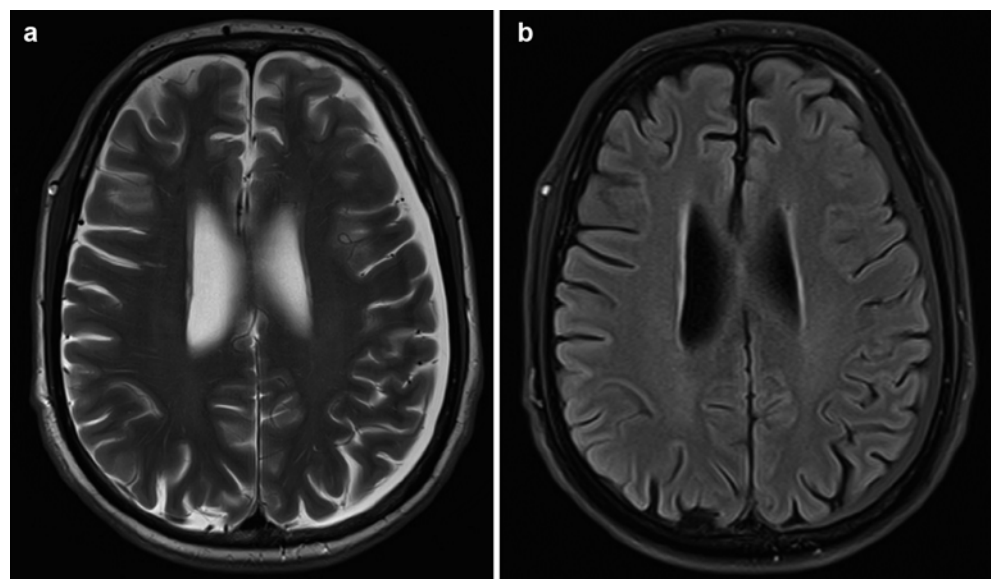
(a, b) Chronic left subdural hematoma. MRI examination, including (a) axial TSE T2-weighted image and (b) axial turbo-FLAIR image with fat saturation. On the T2-weighted scan, the chronic subdural hematoma overlying the left cerebral hemisphere is hyperintense and appears isointense to cerebrospinal fluid (CSF); however, on the FLAIR image, the signal intensity is higher than CSF, indicating a different protein content
